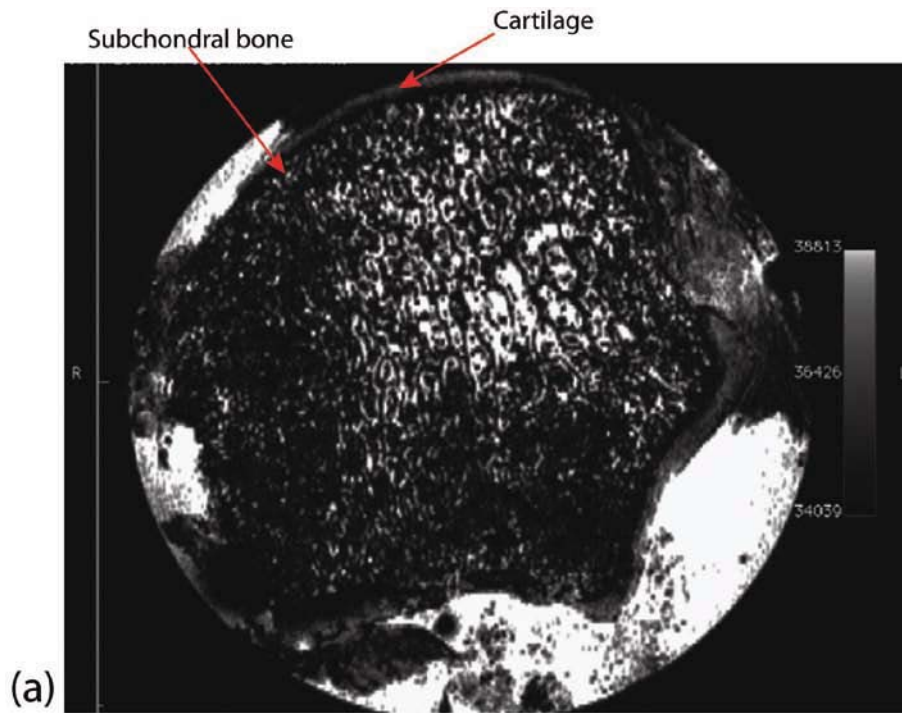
(a) Transverse section image of 1st metatarsal head with 14T MRI. (b) Edges detected in the image shown in Figure 3-2(a) with canny edge detection algorithm
